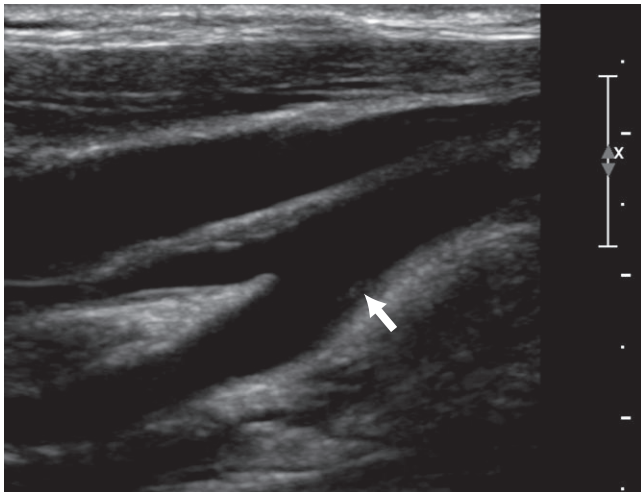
Gray scale ultrasound of the carotid bifurcation confirms that there is only a small plaque at the internal carotid origin (arrow). The plaque barely encroaches into the carotid bulb.
